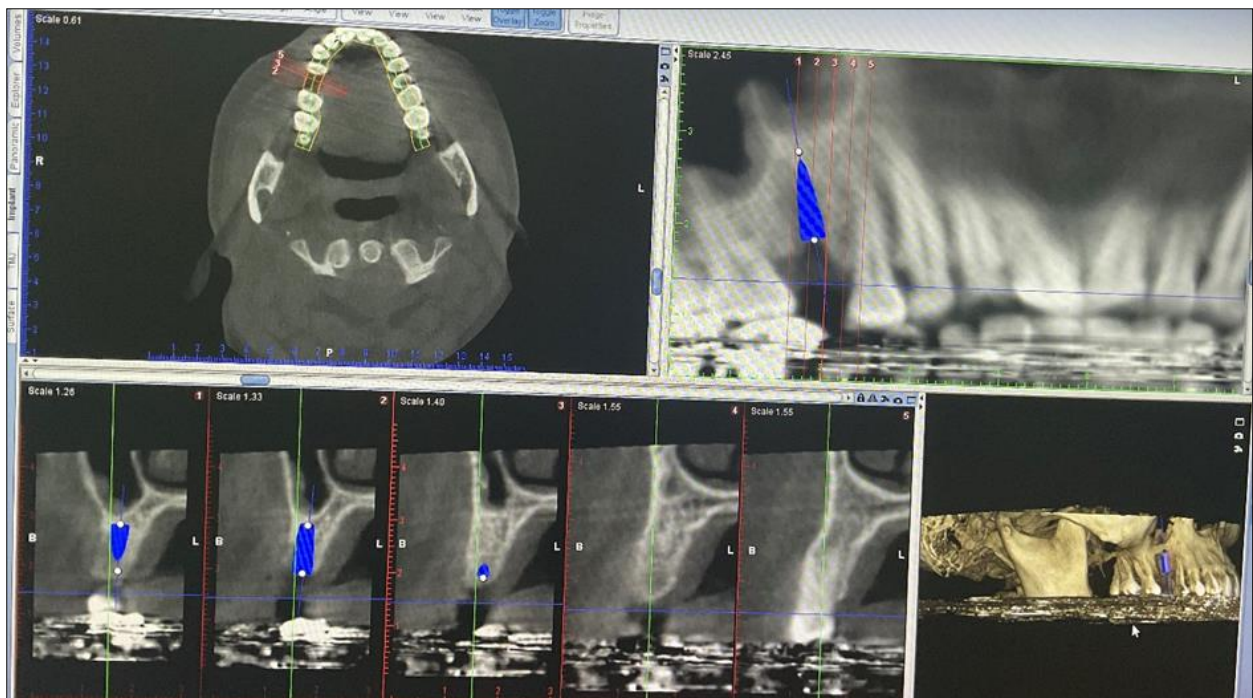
Cone beam computer tomography scans of the maxilla showing D4 type bone
